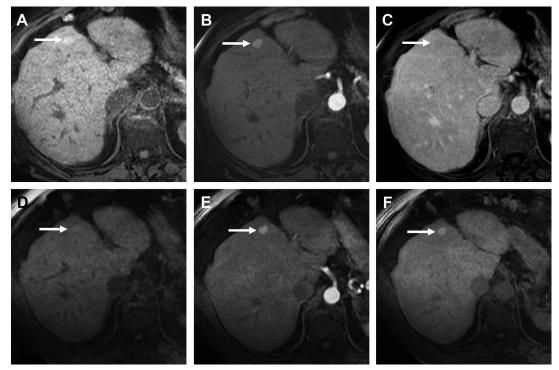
A 67-year-old woman with history of right heart dysfunction. Axial unenhanced T1w MR (*A*) shows a T1 hyperintense lesion (*arrow*) in segment IV. The lesion showed avid enhancement on arterial phase (*B*) and "wash out" appearance on venous phase (*C*). One-year follow-up MR imaging using hepatobiliary agent (*D*–*F*) shows stability in size and retention of contrast during the hepatobiliary phase (*F*). Note the decreased signal intensity of liver and delayed excretion of contrast into the biliary tree on hepatobiliary phase (*F*) suggestive of hepatocellular dysfunction in setting of congestive hepatopathy.
